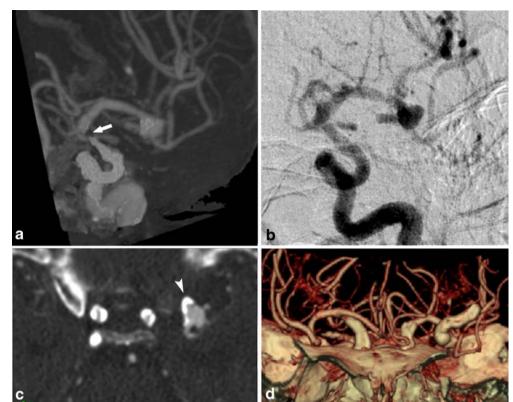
Right ICA large aneurysm of a 75-year-old female patient. MIP images of DE-BR-CTA (a, c) delineate the general shape and configuration of aneurysm as well as DSA (d). VR image of conventional CTA (b) did not show the caudal side of aneurysm with bone
